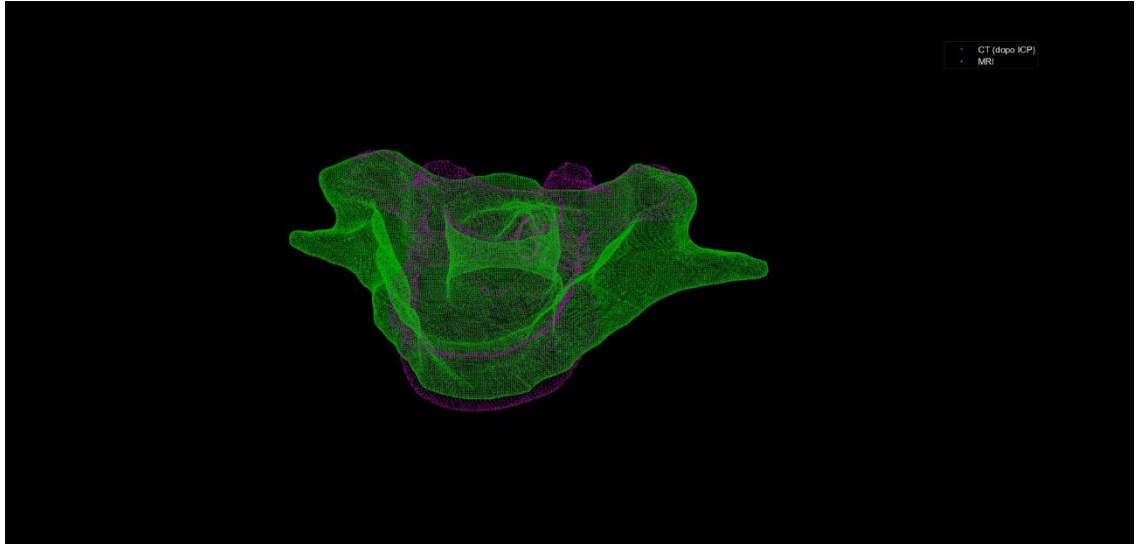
Final Alignment of CT Segmentation to MRI Reference Space for Vertebra T9
